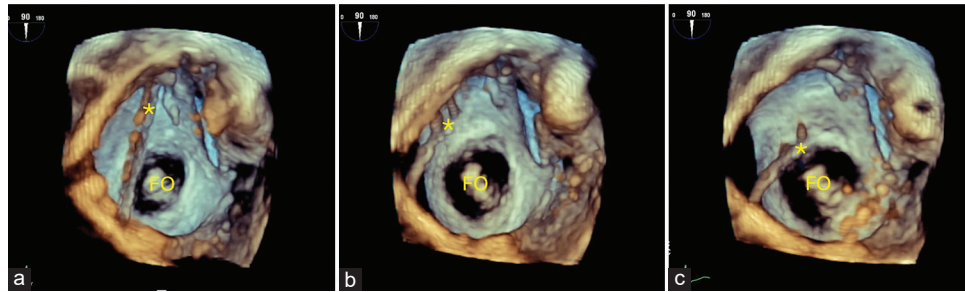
Three dimensional (3D) zoom en face perspective of IAS with the transseptal puncture (TSP) sheath (asterisk) approaching the fossa ovalis (FO) from superior vena cava (a-c). Because of its most usual thin tissue constitution and its spatial orientation in relation to the ultrasound beam, FO often presents “drop out” artefacts on 3D imaging. 3D imaging of IAS may be very useful in case of difficult two dimensional visualization of the TSP sheath descent toward the FO (i.e., too posterior position). SVC: Superior vena cava, FO: Fossa ovalis
